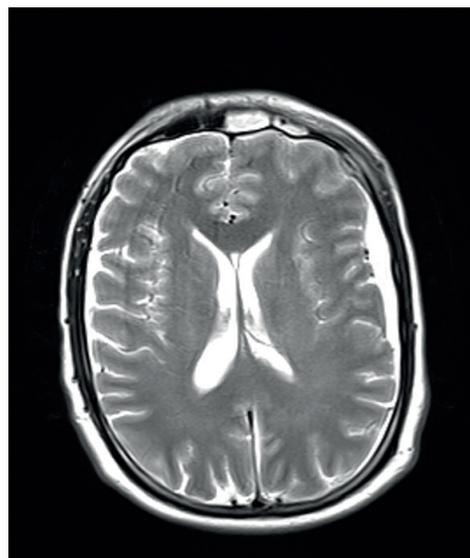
B) T2-weighted MR image taken before treatment. A subdural abscess adjacent to the parietal lobe is noted
